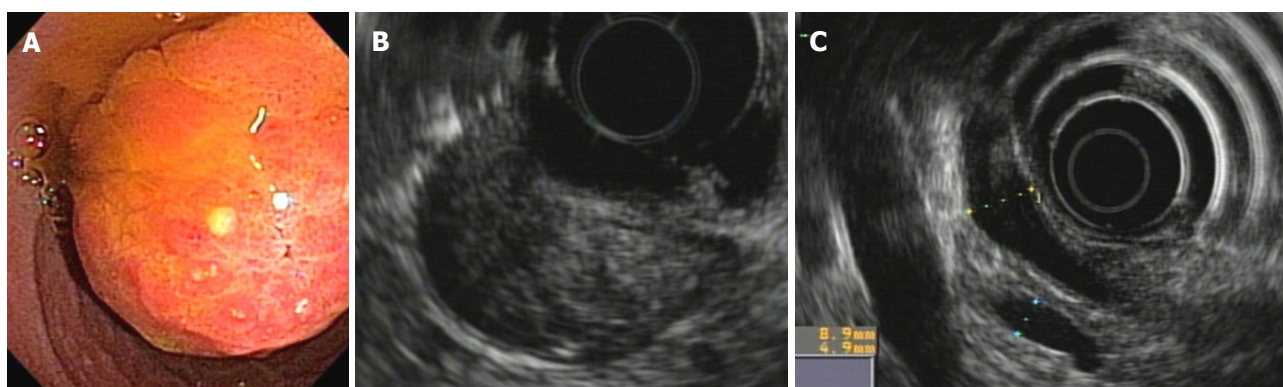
Ampullary tubulo-villous adenoma. A: Endoscopic view; B: Tumor restricted to the duodenal wall as shown in radial endoscopic ultrasound; C: No ductal ingrowth. Endoscopic ampullectomy was indicated.
